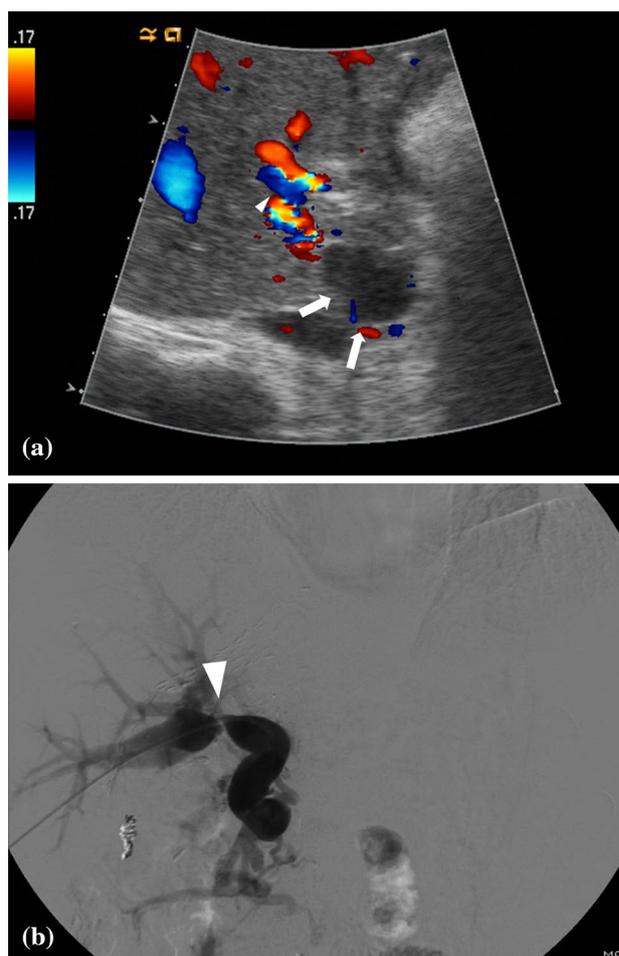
A 50-year-old male with portal vein stenosis after living donor liver transplantation using right lobe graft. a Color Doppler sonogram reveals “no demonstrable color flow” at the recipient portal vein around the anastomosis (arrows), and hepatofugal portal flow at the graft portal vein exhibiting a blue signal (arrowhead), adjacent to the dilated hepatic artery. b Portal venography shows tight anastomotic stenosis (arrowhead). The patient was treated with portal vein stenting, and follow-up Doppler ultrasound revealed restoration of hepatopetal portal flow (not shown)
